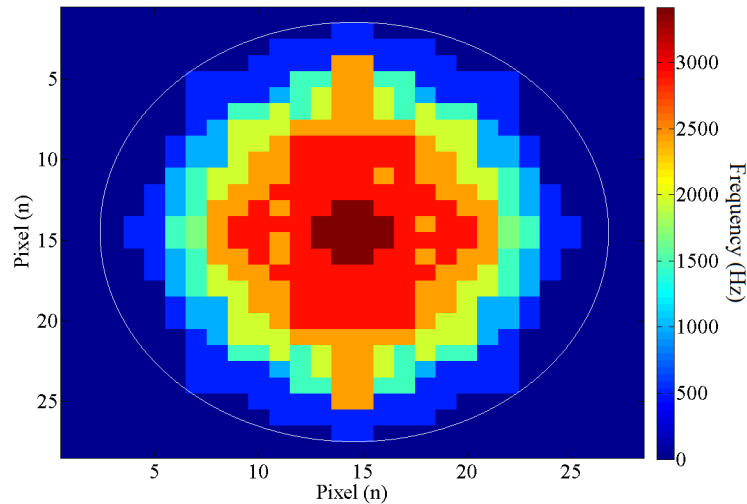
The mode shape (0,1) of the PZ disc vibration obtained by the Doppler frequencies. The scales represent the number of pixels, and the colour code represents the Doppler frequency (in Hz) for each pixel.
